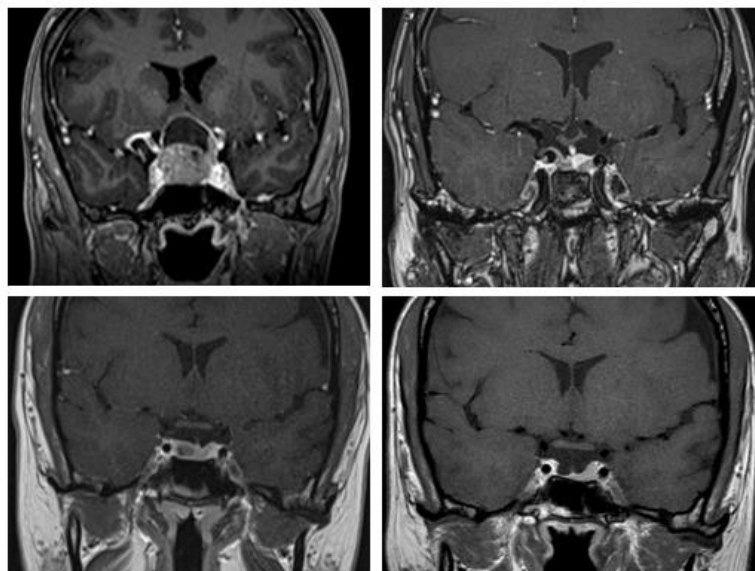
MRI images before and after transsphenoidal pituitary surgery
